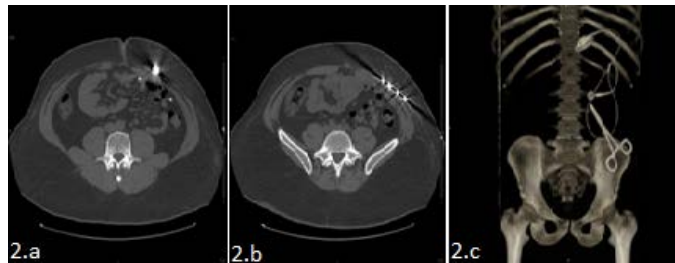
Axial non-contrast enhanced CT of the abdomen confirms a metallic foreign body in the left flank/iliac fossa (2.a; 2.b). 3D reconstruction (2.c) is provided for better understanding.
